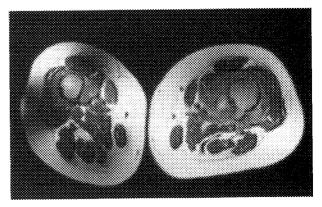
Magnetic resonance imaging of the left thigh showing a mass arising from the femur and extending to the adjacent muscles.
